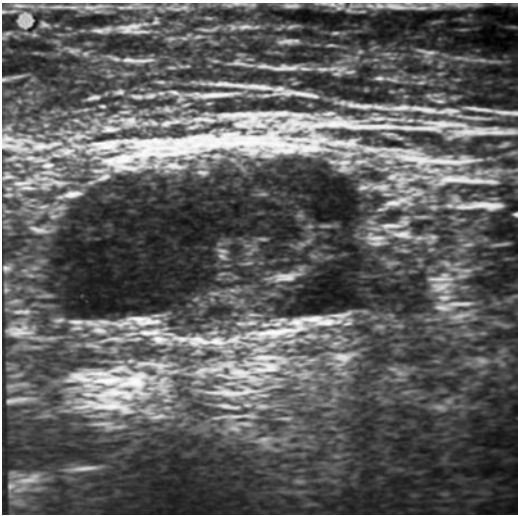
Axillary lymph node metastasis by ultrasound scan
